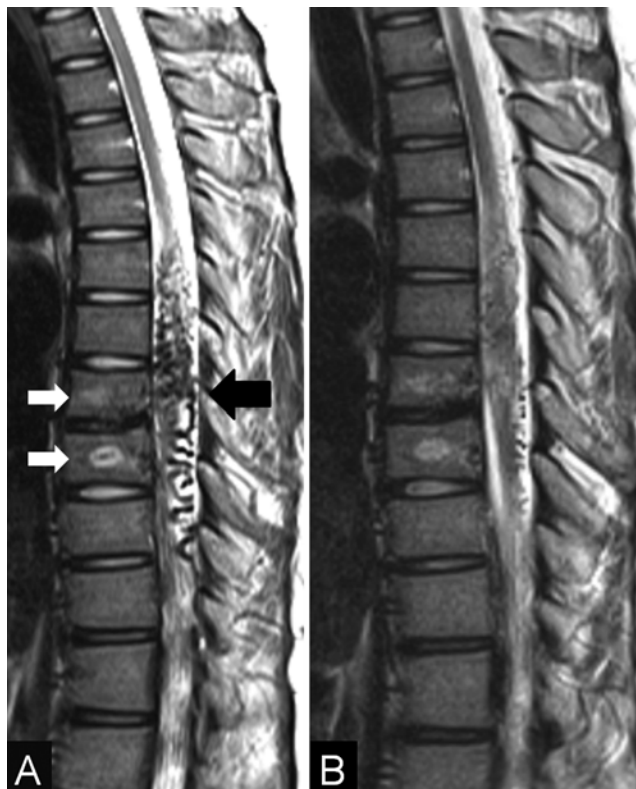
A: Sagittal thoracic T2-weighted MR image demonstrating an intramedullary AVM between T-6 and T-9 (black arrow) and hyperintense signal in the T-8 and T-9 vertebrae (white arrows), suggestive of a vertebral angioma. B: Postembolization sagittal T2-weighted MR image revealing substantial reduction of the AVM-related flow voids.
